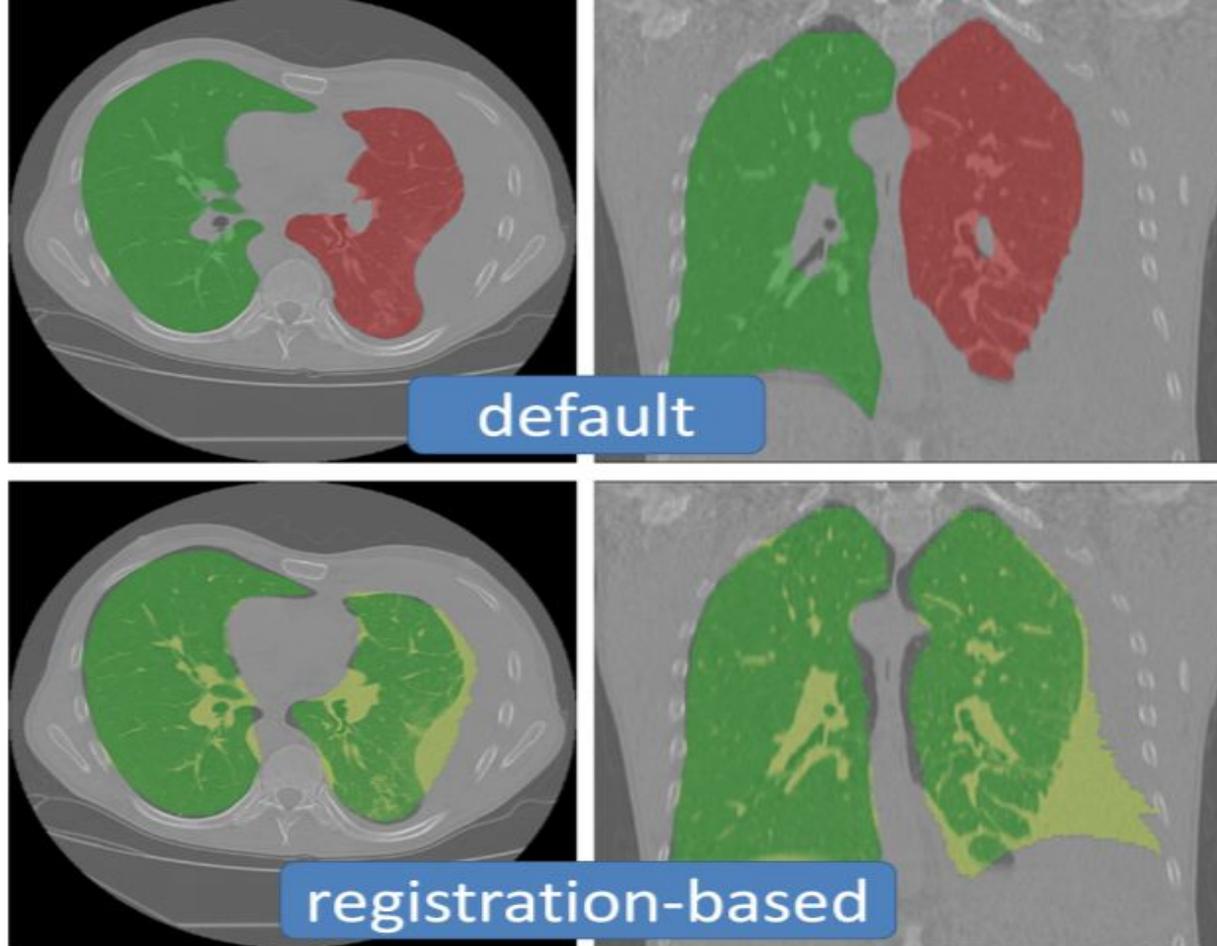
CT image of a TB patient having pleurisy with the default lung masks (top) and the lung masks obtained via registration-based approach (bottom).
